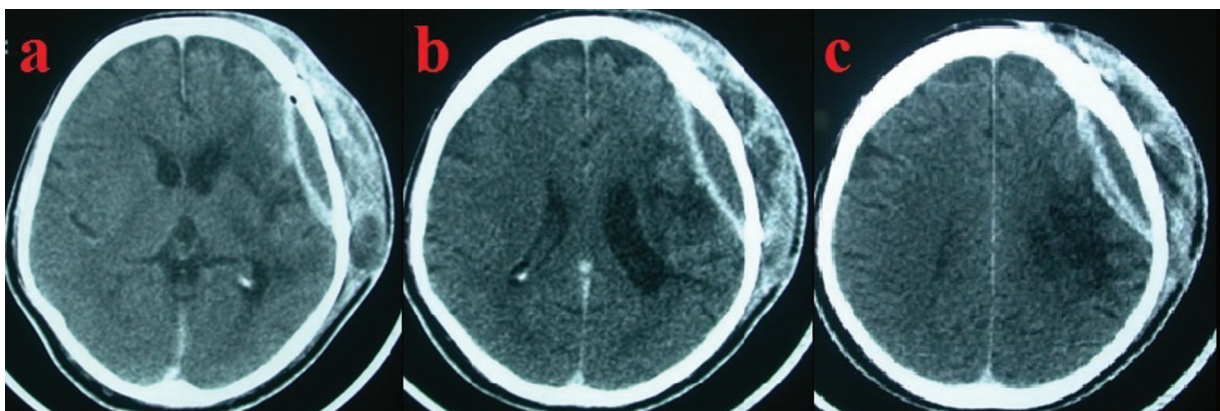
Contrast-enhanced CT scans (A–C) showing abscess with enhancing walls both outside and inside the replaced bone flap.
